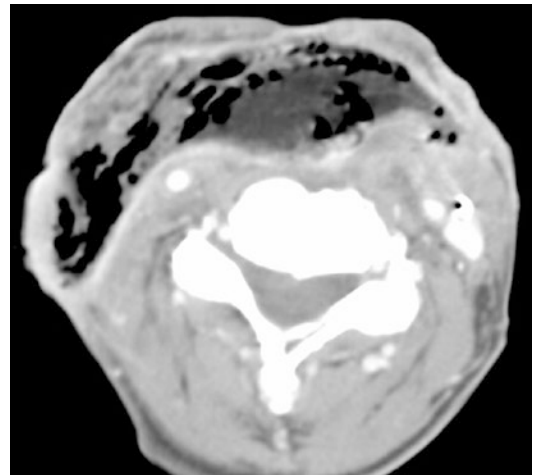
Axial contrast-enhanced CT image. A few weeks before this CT study, total laryngectomy was performed, with neopharyngeal reconstruction by a pectoralis major flap. The patient suffers now from persistent fistulization. Throughout the pectoralis major flap, large, confluent gas bubbles are visible, indicating flap necrosis. Flap necrosis was surgically confirmed
